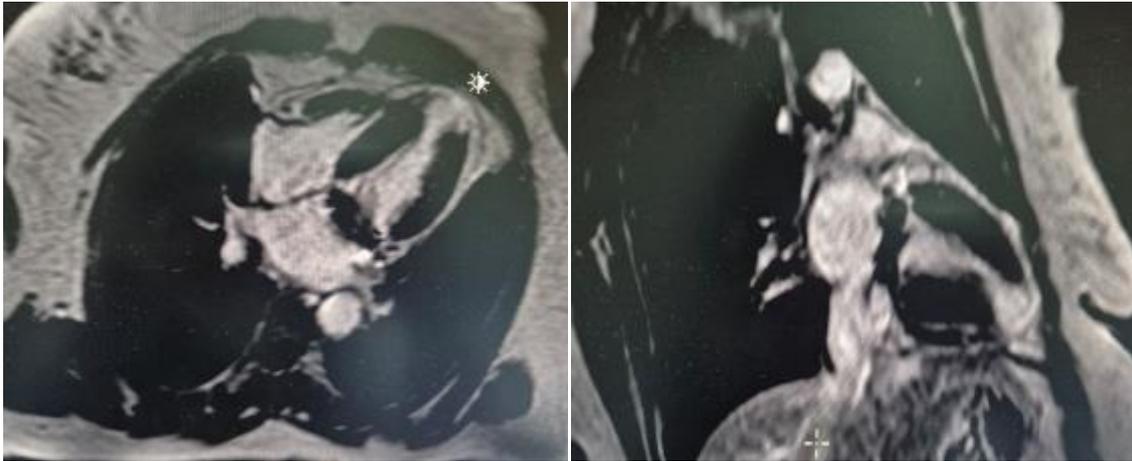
Late gadolinium enhancement sequences on cardiac MRI showing transmural enhancement at the apex of the left ventricle.
